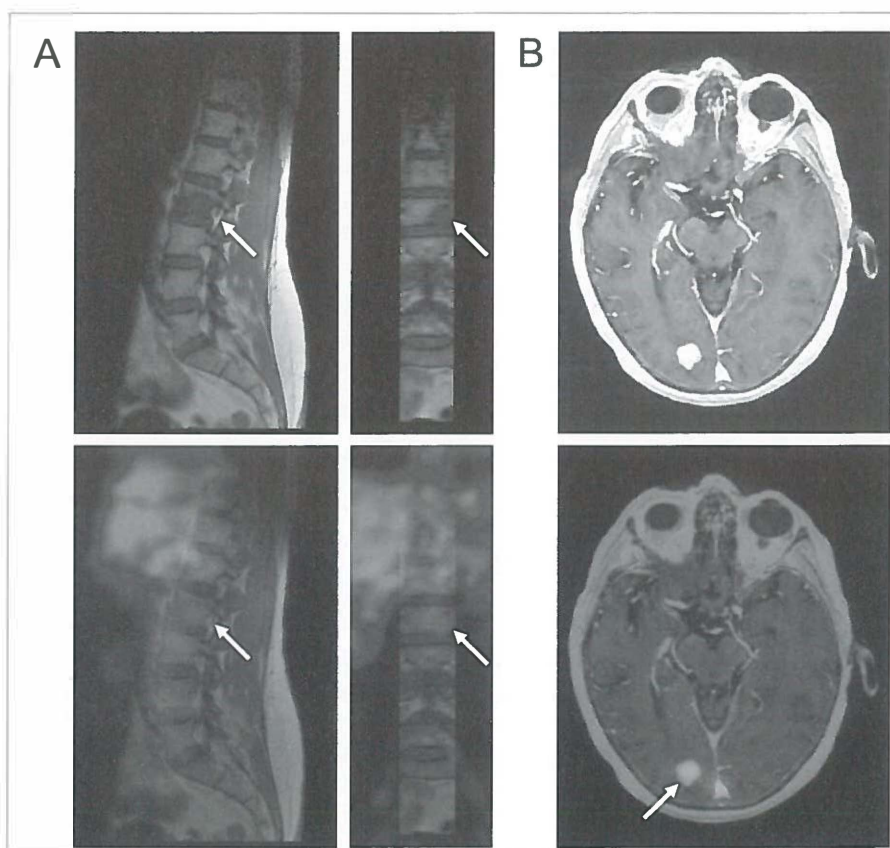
Examples of HER2-PET MRI fusion images. HER2 status of a vertebral metastasis known on MRI unapproachable for biopsy was revealed by ⁸⁹Zr-trastuzumab uptake on HER2-PET (A). Example of HER2-PET detected unknown brain lesion, which was later confirmed by MRI (B). Arrow indicates lesions. See page 171 for full color image.
